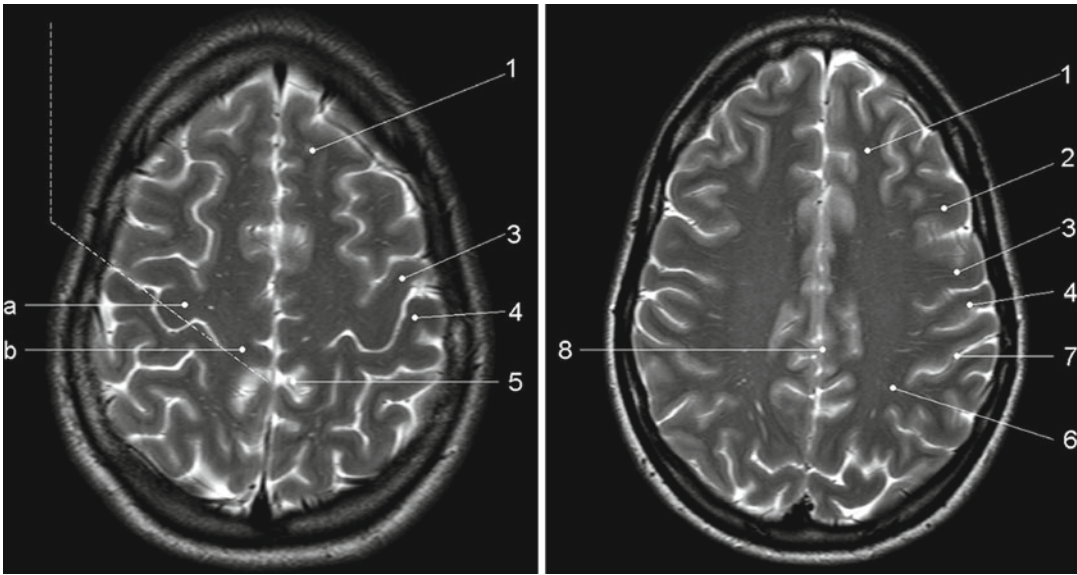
Axial T2-weighted TSE MR images. 1 superior frontal gyrus, 2 medial frontal gyrus, 3 precentral gyrus, 4 postcentral gyrus, 5 “pars bracket”, cingulated sulcus, 6
